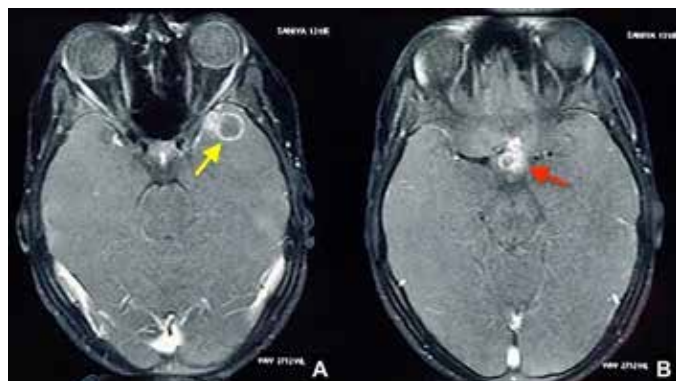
Post-Gadolinium T1 weighted axial MRI images show (A) conglomerate ring-enhancing lesions in the left anterior temporal lobe (yellow arrow). The intraorbital and intracanalicular segments of optic nerve appear normal. (B) Similar ring-enhancing lesions noted in the suprasellar cistern involving the optic chiasma (red arrow).
